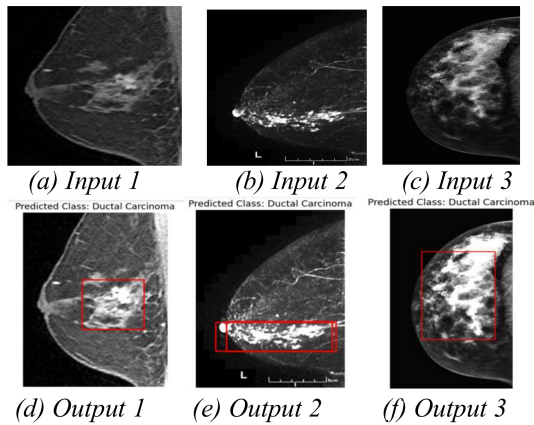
(A-C) the input of breast Magnetic Resonance Imaging (MRI) image and (D-F) the output of the cancer region and Ductal Carcinoma (DC) classification.
